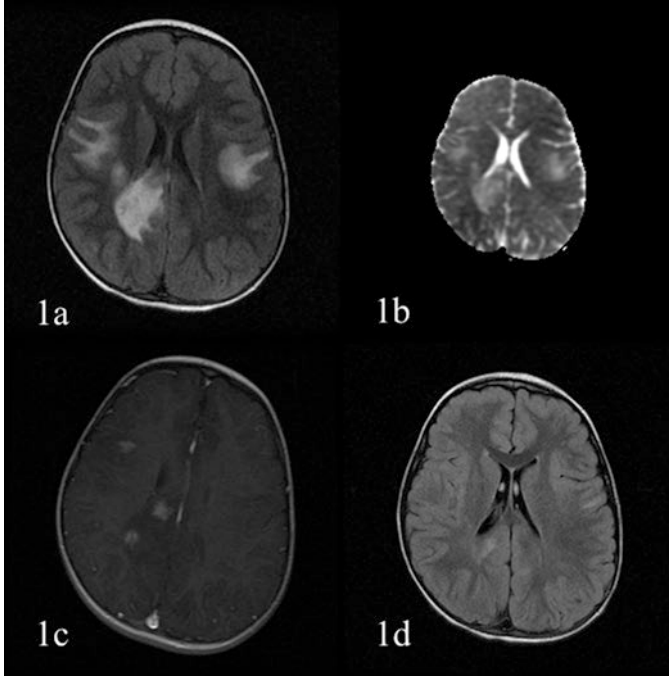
(a) Axial T2-weighted FLAIR image reveals extensive white matter signal hyperintensity extending from the subcortical white matter of the peri-rolandic areas to the centrum semiovale, with T2 prolongation also seen across the corpus callosum. (b) Diffusion studies show increased diffusivity of the involved areas. (c) T1-weighted imaging demonstrates heterogeneous enhancement pattern. (d) Follow-up T2-weighted FLAIR image obtained 3 months after onset shows almost-complete resolution of lesions
